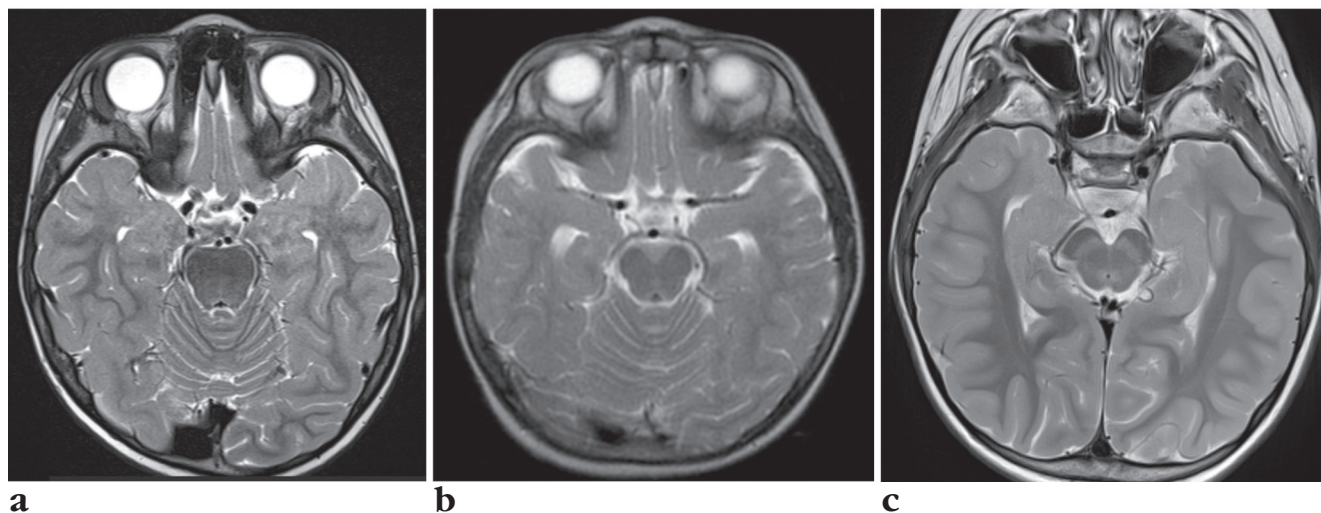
Magnetic resonance imaging results:
